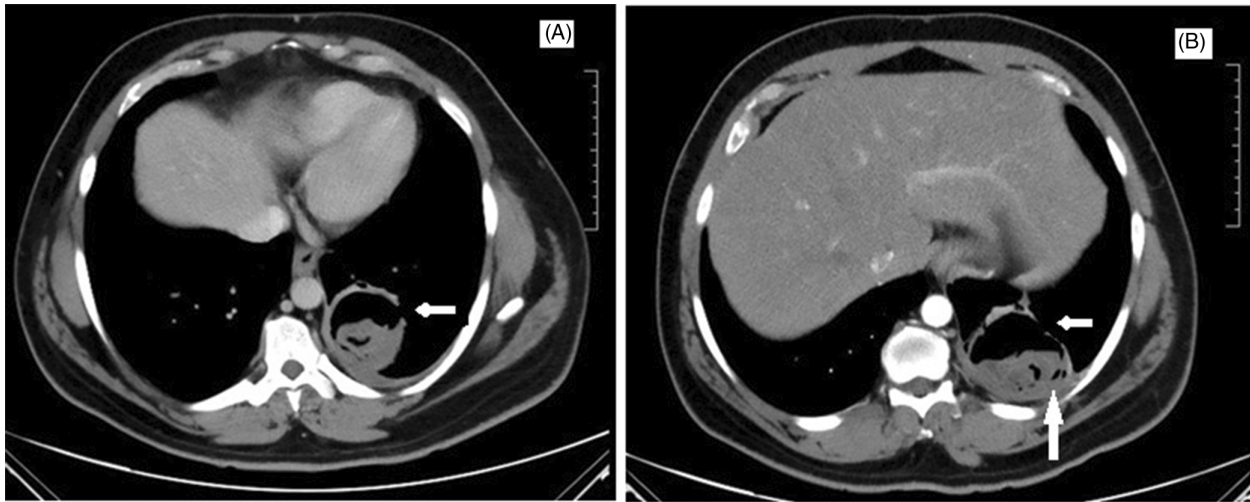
(A) CT scan axial section showing left lower lobe cystic lesion with intra cystic material, probably ruptured hydatid cyst. (B) Ruptured cyst causing effusion, visualized liver shows absence of any cyst in the liver.
